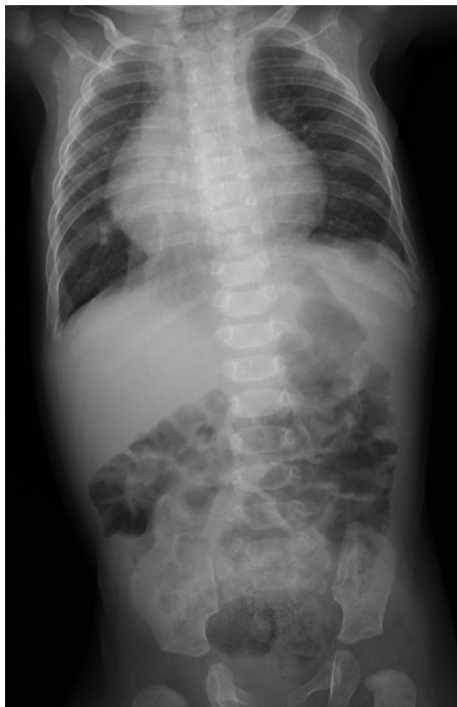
Chest and abdominal X-ray findings at one year old. Chest X-ray indicated no recurrence of chylothorax or left CHD at one year old
